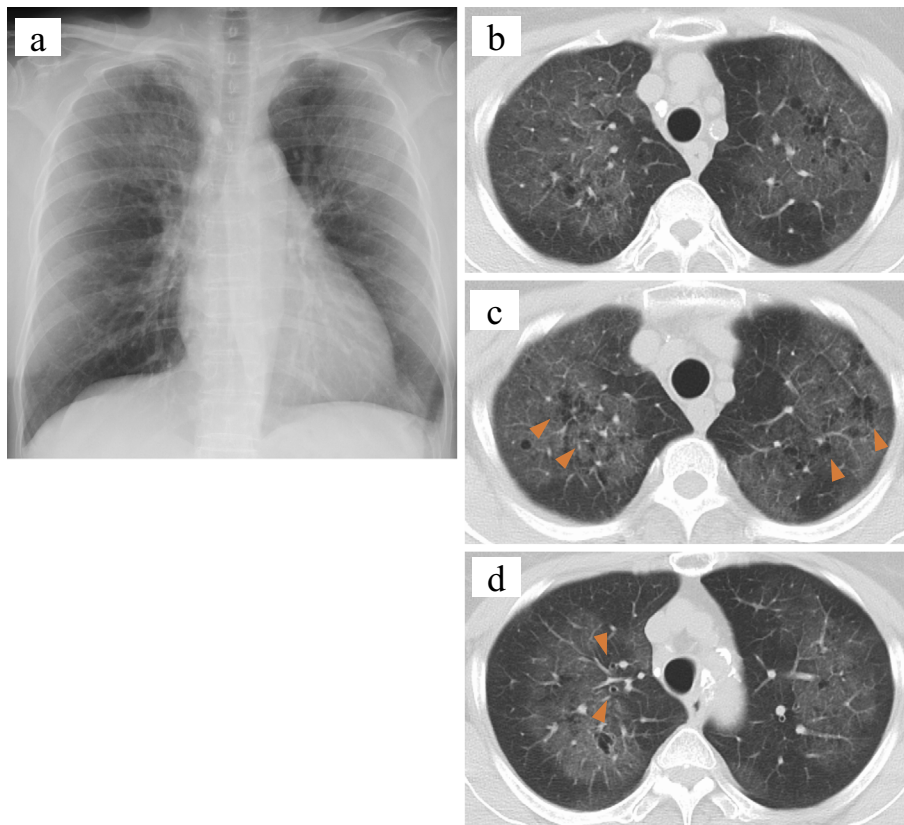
Chest imaging findings on admission. (a) A chest radiograph shows symmetric pale ground-glass opacities (GGOs) in the bilateral upper lung fields. Chest computed tomography also shows (b) GGOs in the bilateral upper lung fields and (c) emphysematous changes (arrowheads) with (d) bronchial dilatation (arrowheads).
